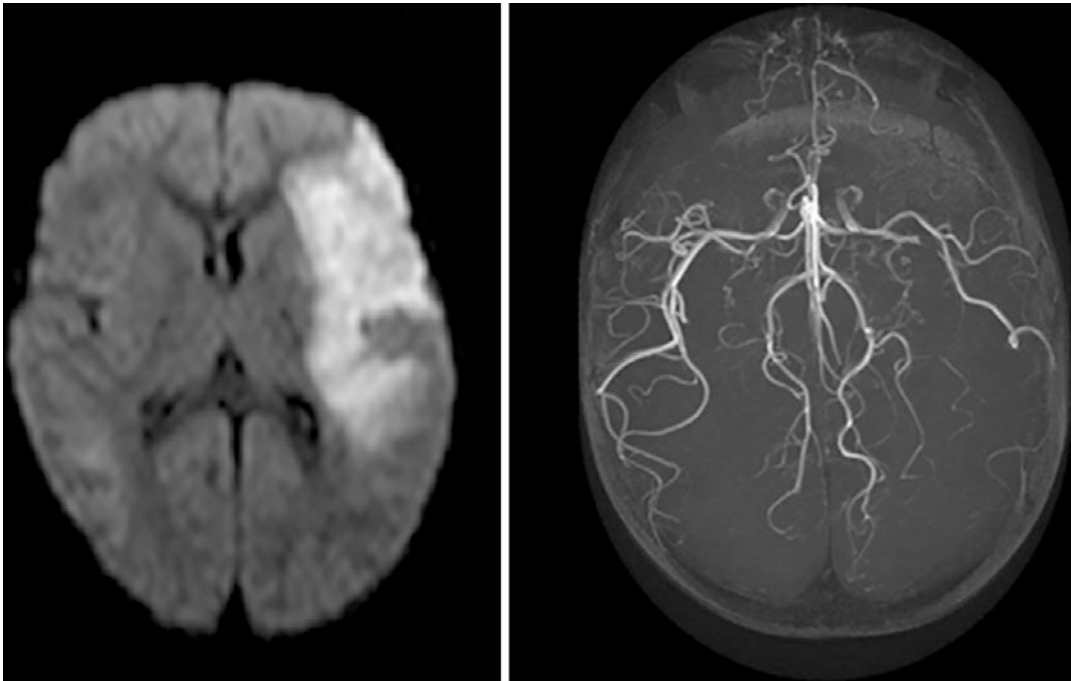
Acute Left MCA Infarct. Right: MRI diffusion weighted imaging shows restricted diffusion in the left MCA territory. Left: 3D vessel reconstruction showing an
